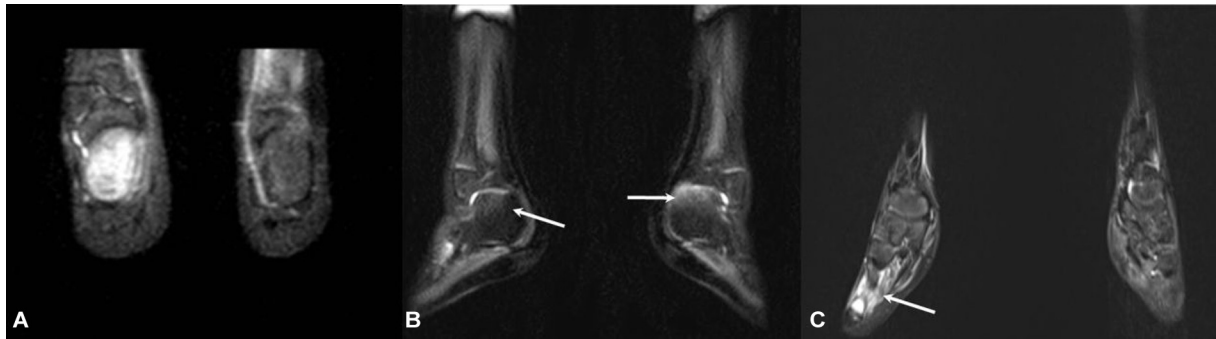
Chronic nonbacterial osteomyelitis (CNO) with small bone involvement in different patients. (A) Calcaneal involvement in a 12-year-old female who complained fleeting bone pain. Coronal short tau inversion recovery (STIR) whole body magnetic resonance imaging (WBMRI) image demonstrates hyperintense signal in right calcaneus, suggesting involvement. (B and C) In another 11-year-old who complained of bilateral heel pain, external rotation of the feet during scanning allowed better evaluation of the calcaneus in the sagittal view (B) in comparison with a routine coronal view. Mild hyperintense signal is seen in bilateral calcaneal bones (arrows, B), which could be attributed to involvement. (C) An additional lesion in the right metatarsal (arrow, C) is also observed with associated periostitis.
